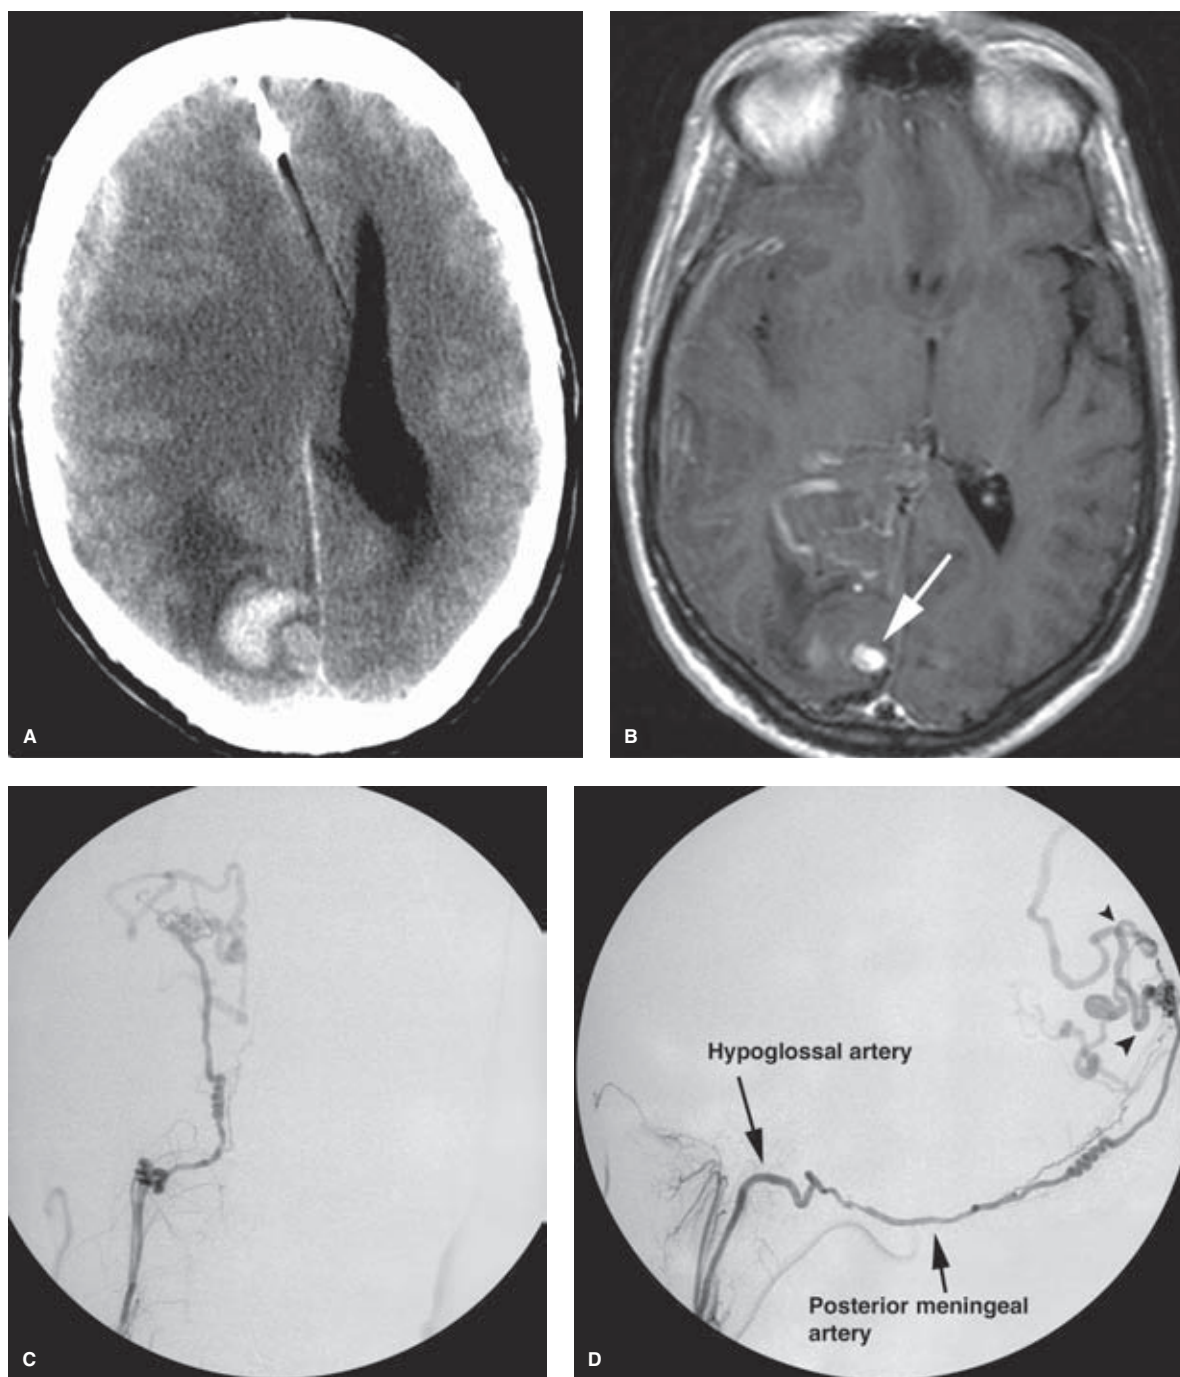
(A–D) Small dural AVF presenting with massive intracranial complications. This elderly patient presented with abrupt onset of a right intraparenchymal bleed and a large right subdural hematoma, which had to be evacuated emergently, shown on a noncontrast CT (A). A postoperative MRI T1-weighted image with gadolinium shows numerous right occipital enhancing vessels with a large enhancing aneurysmal structure (arrow in B). The eventual diagnosis was nailed down to a tiny (<1 cm²) area of the occipital calvarium, where a dural AVF was deriving supply from the right ascending pharyngeal artery (C, AP view; D, lateral view) via the hypoglossal branch of the neuromeningeal trunk, which in turn became the posterior meningeal artery of the posterior fossa extending to the AVF. From the AVF, two pial veins extend centripetally, causing venous hypertension with a ruptured pseudoaneurysm, explaining the original presentation. An endovascular treatment was attempted, but access along the posterior meningeal artery proved too difficult due to tortuosity not well seen on these images. The patient was successfully treated surgically by disconnection of the AVF from the pial veins.
